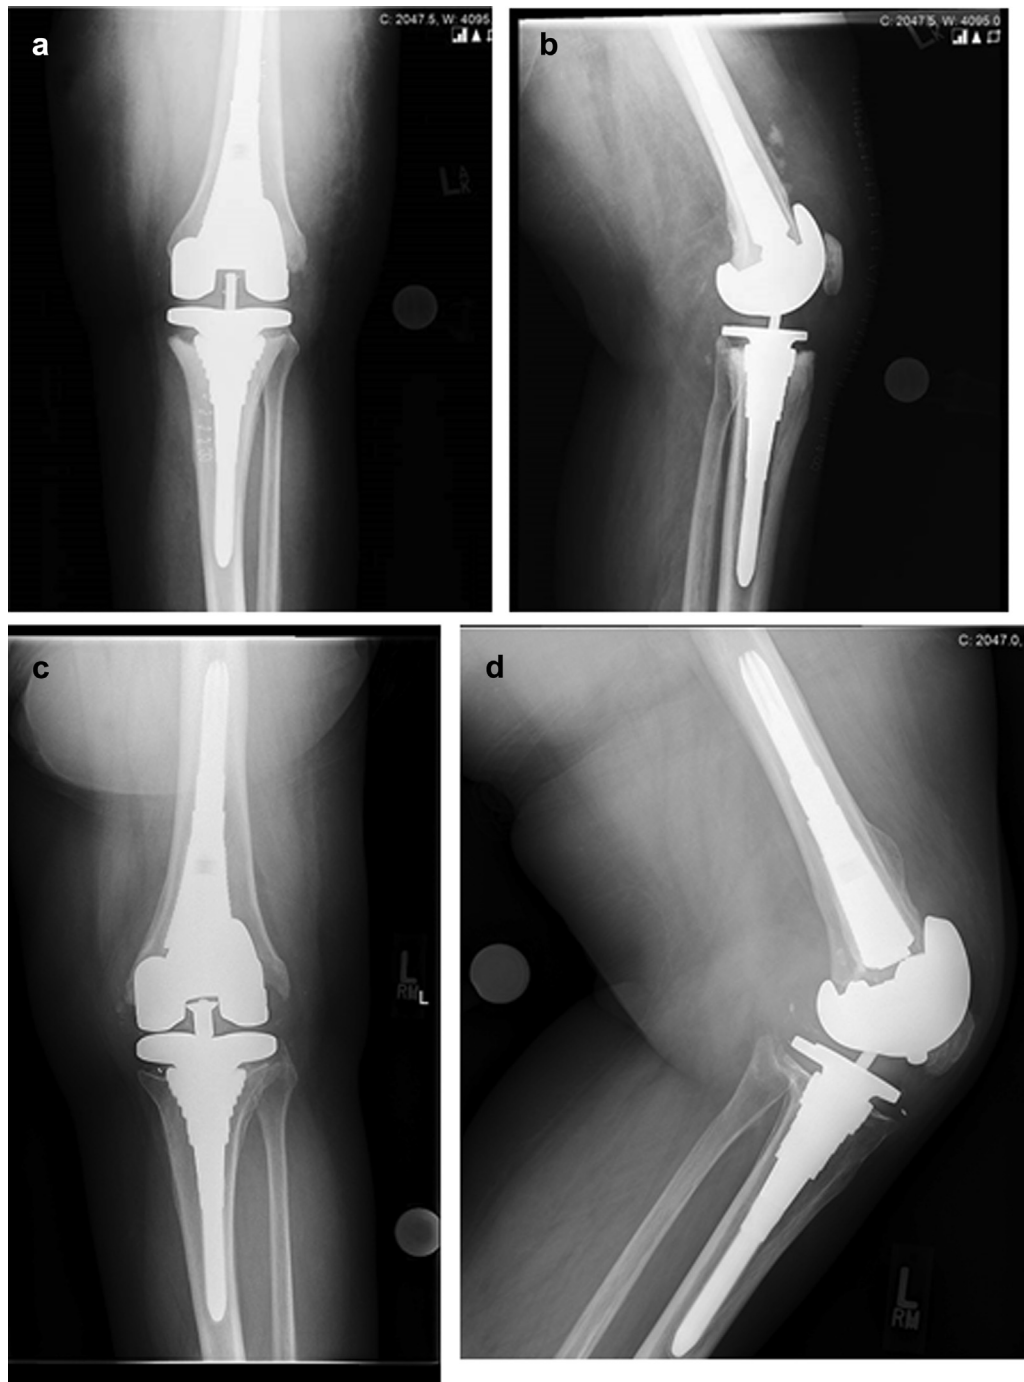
Anteroposterior (AP) (a) and lateral (b) radiographs obtained at revision surgery in 2010. 4.5 years later, the patient presented with onset of pain and AP (c) and lateral (d) views confirmed fracture of the implant and taper disengagement from the metaphyseal stem.
